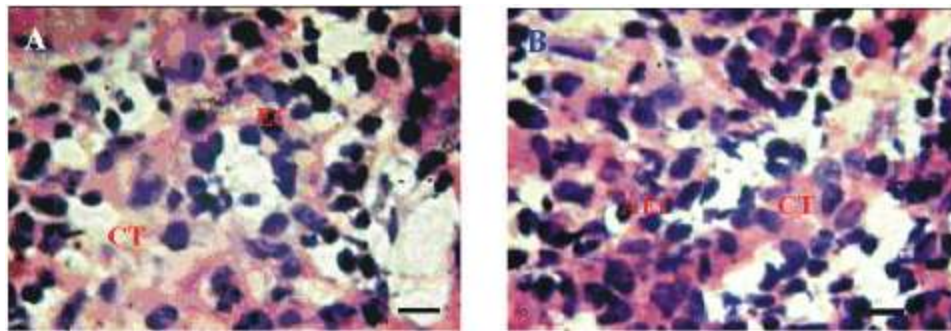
(A) Intact androgenic gland showing the epithelial cells (EC) and connective tissue (CT). (B) Ablated prawn showing the abundance of epithelial cells (AEC) along with connective tissue (CT). Note increase the number of the epithelial cells in ablated prawn. Bar: 50  $\mu$ m.
